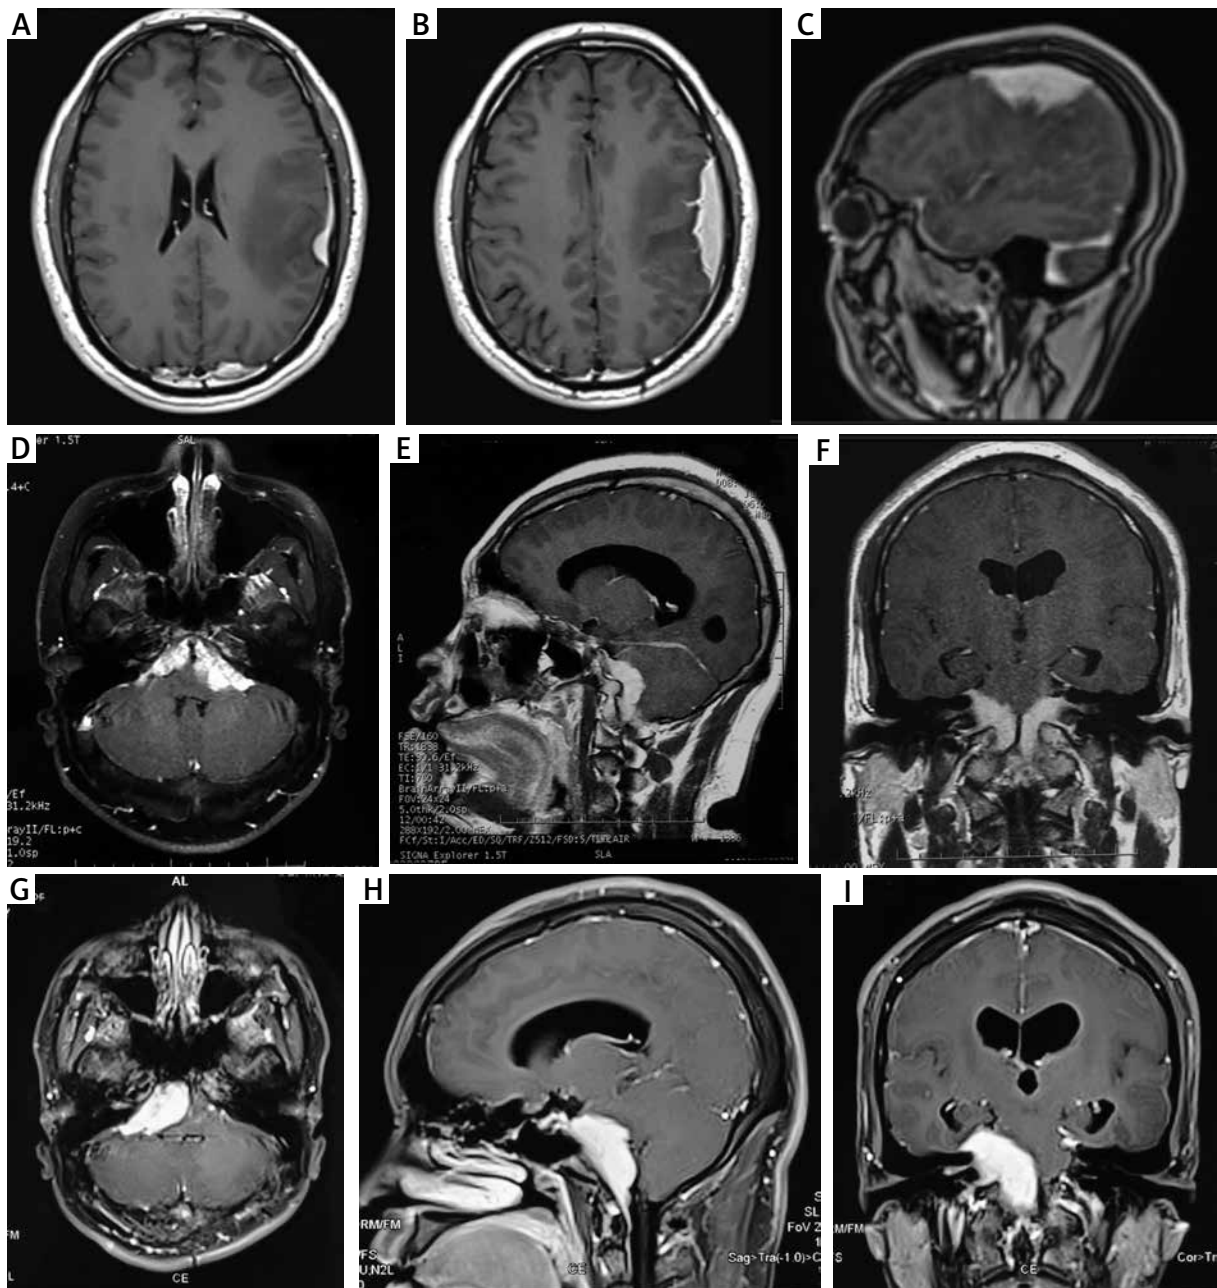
Neuroimaging findings. A-C) T1-weighted contrast-enhanced MRI scan showing multiple masses in the left frontal, parietal, and temporal regions and bilateral occipital meningeal. D-F) Enhancement lesions in bilateral cerebellopontine angle regions and extending into the left foramen magnum. G-I) Progression of the lesion in the right cerebellopontine angle region.
